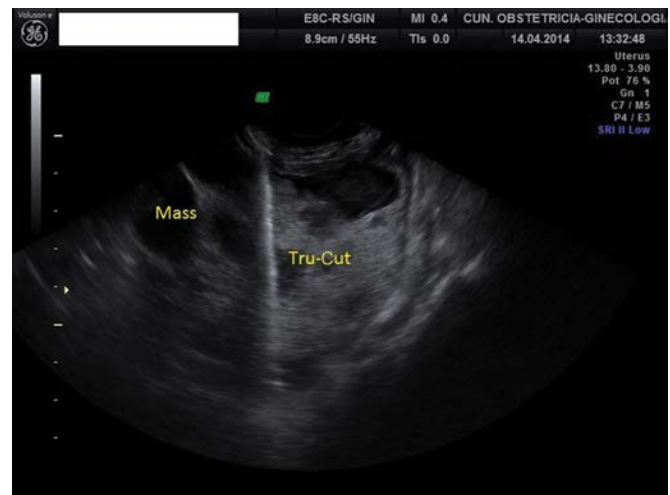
Transvaginal ultrasound showing the Tru-Cut needle passing through a cystic-solid lesion suspected as a pelvic recurrence from ovarian cancer.
